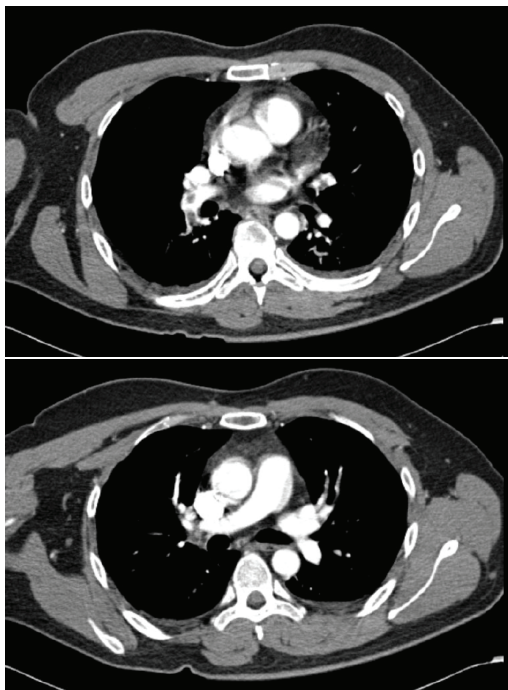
Computed tomographic (CT) angiography of the chest revealed pulmonary embolism
